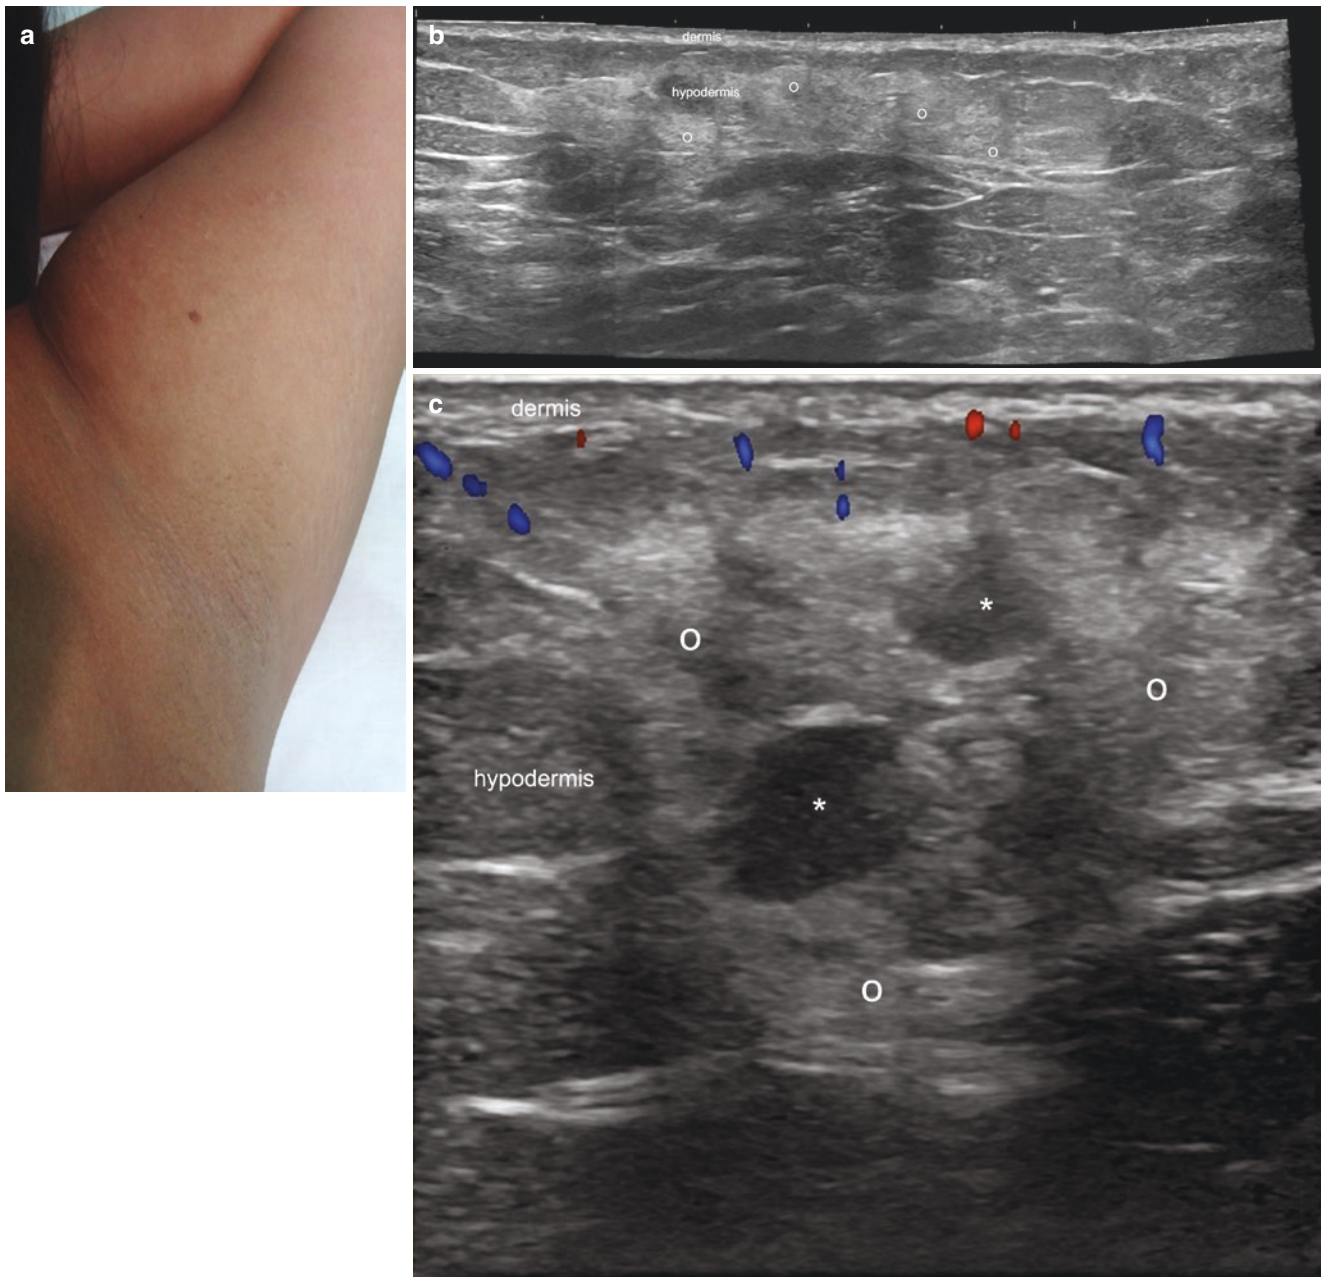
Cryolipolysis. (a) Clinical image of a patient with a history of cryolipolysis 6 months previously, who palpates lumps in the inner and proximal aspect of the left arm close to the axillary region. (b) Ultrasound (greyscale, longitudinal view; left arm) demonstrates increased echogenicity of the hypodermal fat (o). (c) Color Doppler
